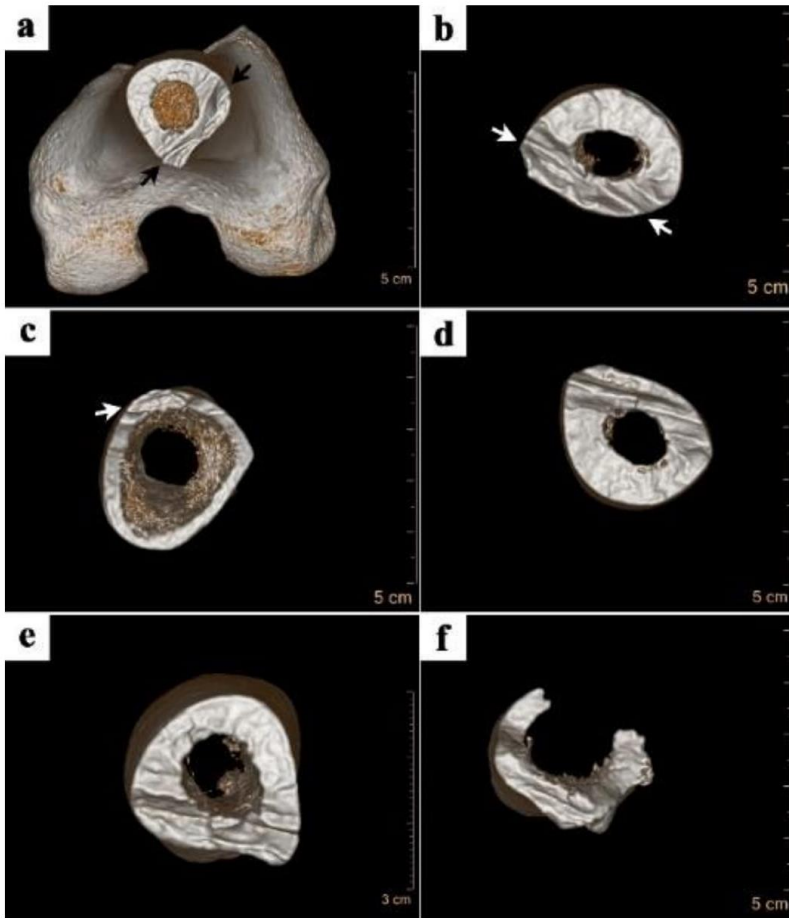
Layered breakage as seen in the 3D reconstructed CT scan.
